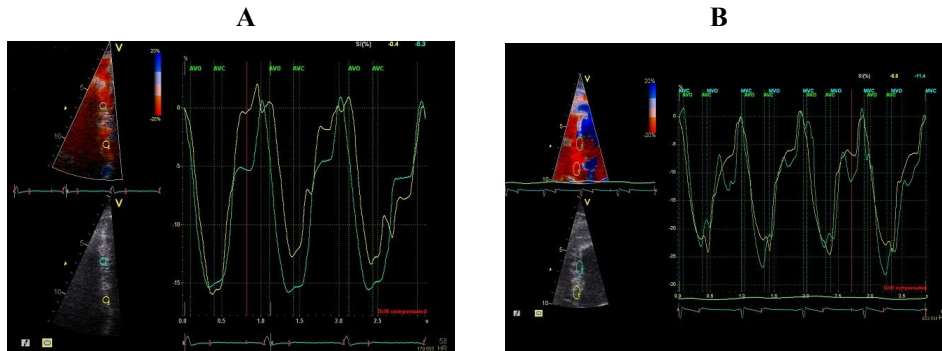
Doppler strain echocardiography. Longitudinal strain curves over multiple heart cycles from the septal basal (yellow) and septal mid (green) segments in (A) patient with CKD and (B) healthy control. Peak strain at the aortic valve closure is significantly reduced in both the basal and mid segments in CKD compared with control subject.
